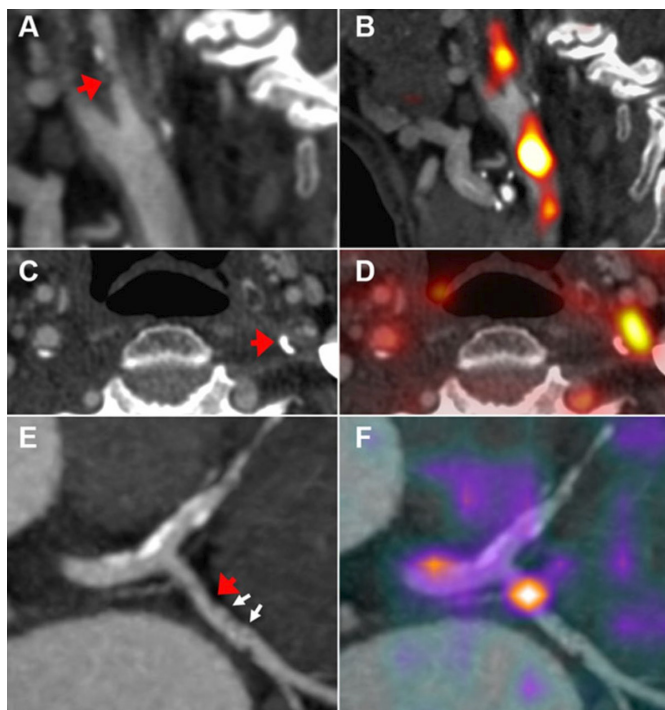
Positron emission tomography (PET) inflammation imaging. CT angiography of symptomatic left internal carotid stenosis (arrows); sagittal (A) and axial (C) views. (B and D) Fused 18F-fluorodeoxyglucose (FDG) PET-CT demonstrates the high uptake related to the symptomatic carotid plaque. (E) Coronary CT angiogram of left circumflex coronary artery lesion (red arrow) with spotty calcification (white arrows); (F) fused 68Ga-DOTATATE PET-CT exhibits a high signal in relation to an inflamed coronary plaque. Cited from Imaging Atherosclerosis, Tarkin et al. 2016²⁰
